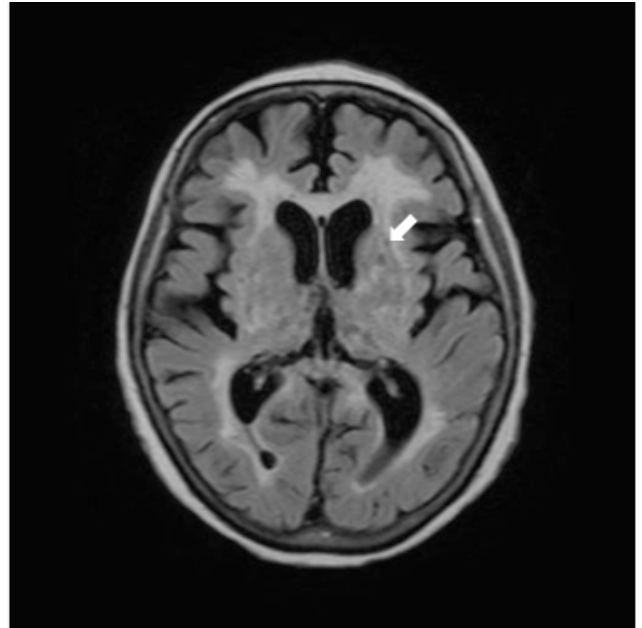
MRI (magnetic resonance imaging) with FLAIR (fluid attenuated IR) showed high dense area in white matter in peripheral area of lateral ventricle, suggesting lacuna infarction due to multiple microthrombosis (leukoaraiosis) (arrow).
